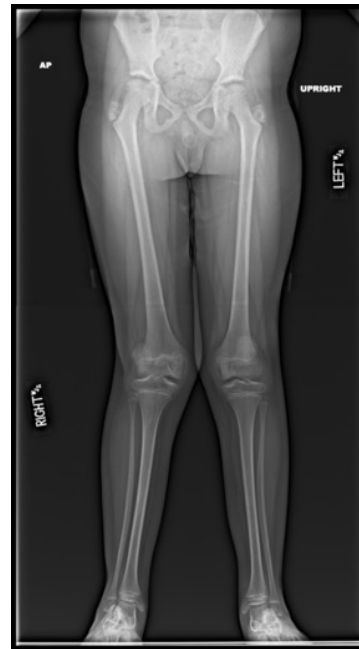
Anteroposterior standing hip to ankle X-ray in a patient with valgus deformity and right sided patellar dislocation.
